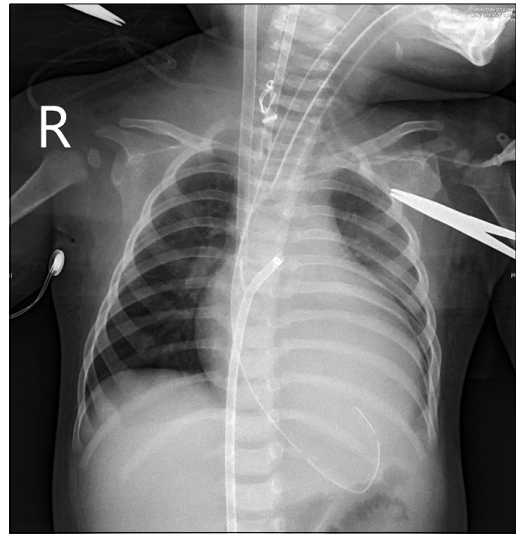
Chest X-ray showed left atrial venting cannula insertion through right femoral vein.
